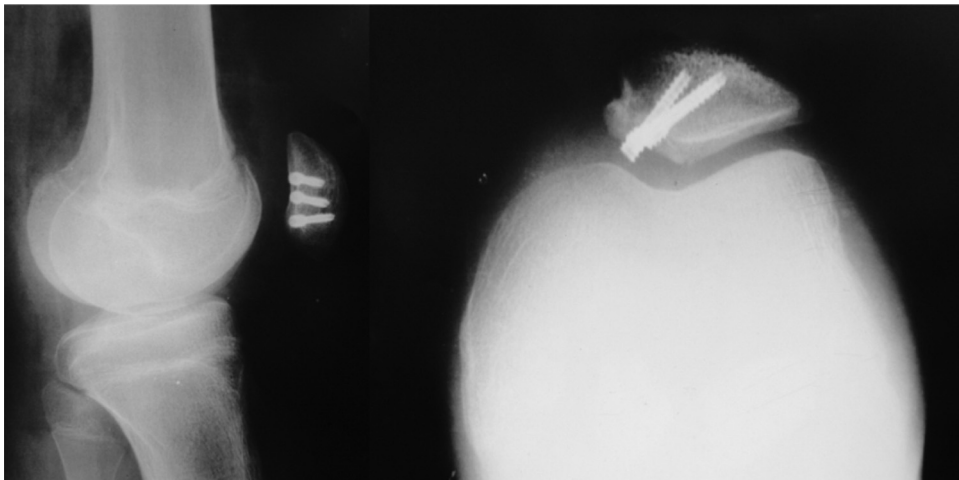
Postoperative radiography of the right knee.
